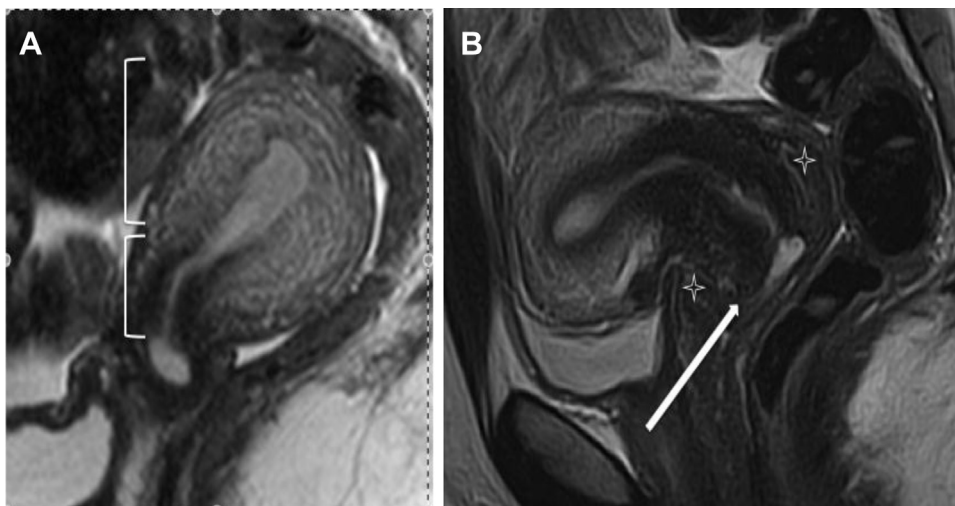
(A) After surgery, the cervical length was approximately one-third of the total length of the uterus and cervix and the zonal anatomy of the endocervical canal showed normal magnetic resonance imaging characteristics. The anterior and posterior vaginal fornices were not well visualized, which was presumed to be the result of the upper vaginal septum that caused distension and distortion of the anatomy in this region. (B) A normal cervix of a patient of the same age, as a comparison, shows well demarcated fornices (stars) and clear contours of the ectocervix (arrow). The length and zonal anatomy of the cervical canal are similar to that seen in patient 1.
